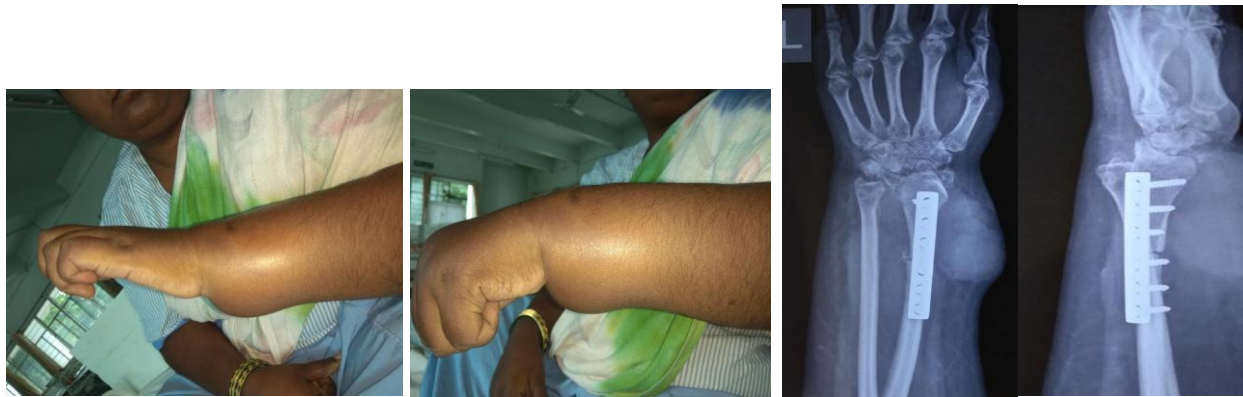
Post operative Range of movements with recurrence (clinical picture and Xray)
